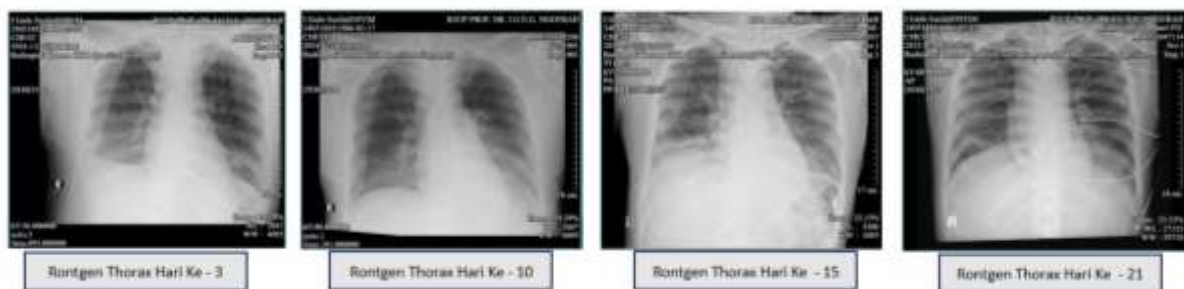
Thoracic X-rays
